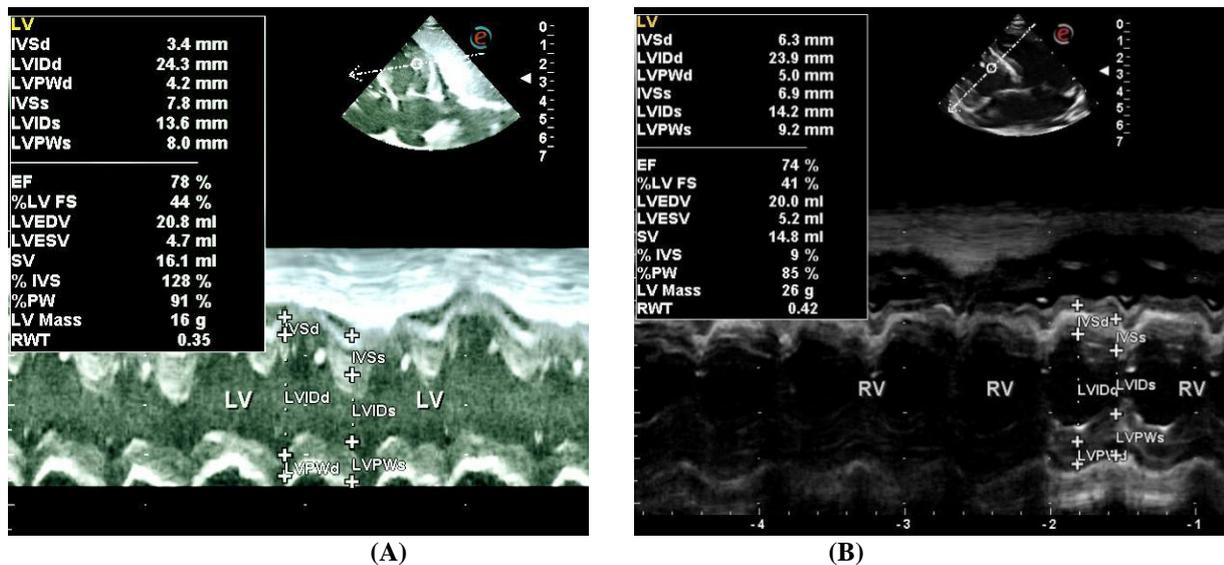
M-mode Echocardiography. (A) LV volumetric estimation; (B) RV volumetric estimation.
